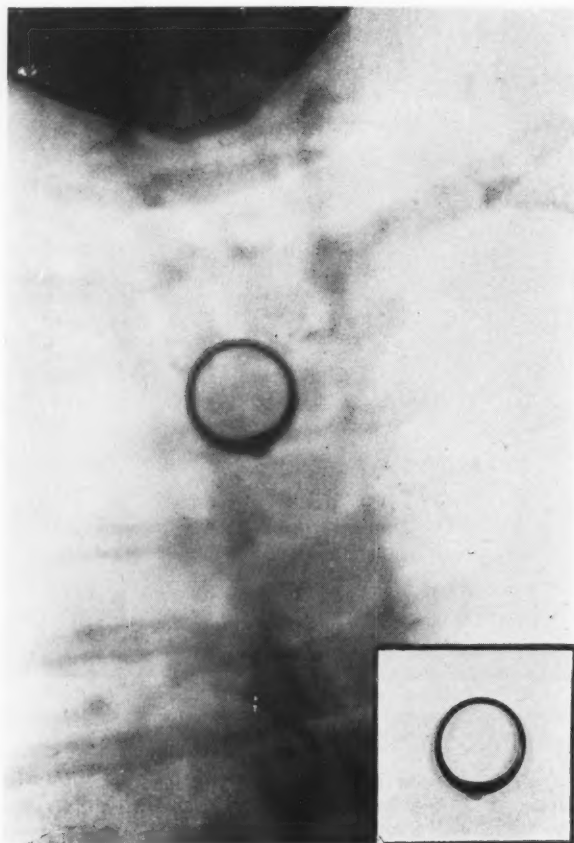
A. Roentgenogram showing ring just above the level of the aorta.
